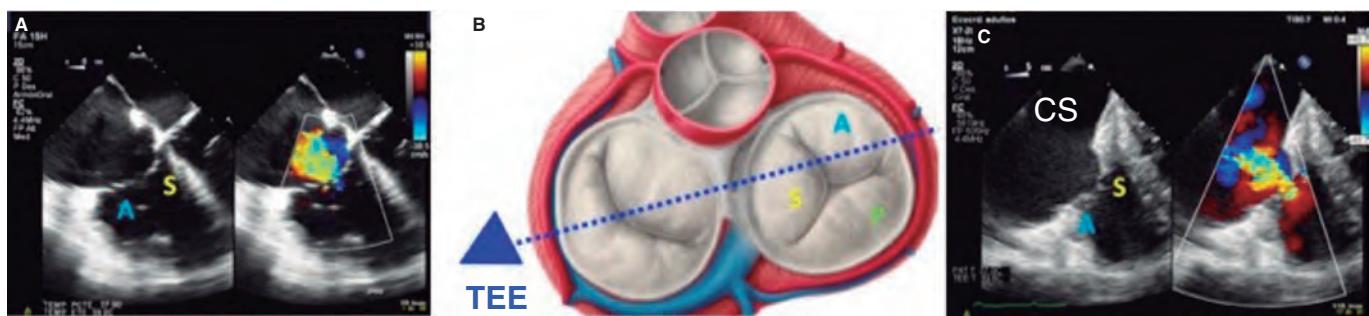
A: mid-esophageal 4-chamber view showing the septal leaflet and the anterior leaflet. B: imaginary view in the 4-chamber view. C: deep transesophageal view. A, anterior; TEE, transesophageal echocardiogram; S, septal; CS, coronary sinus.
